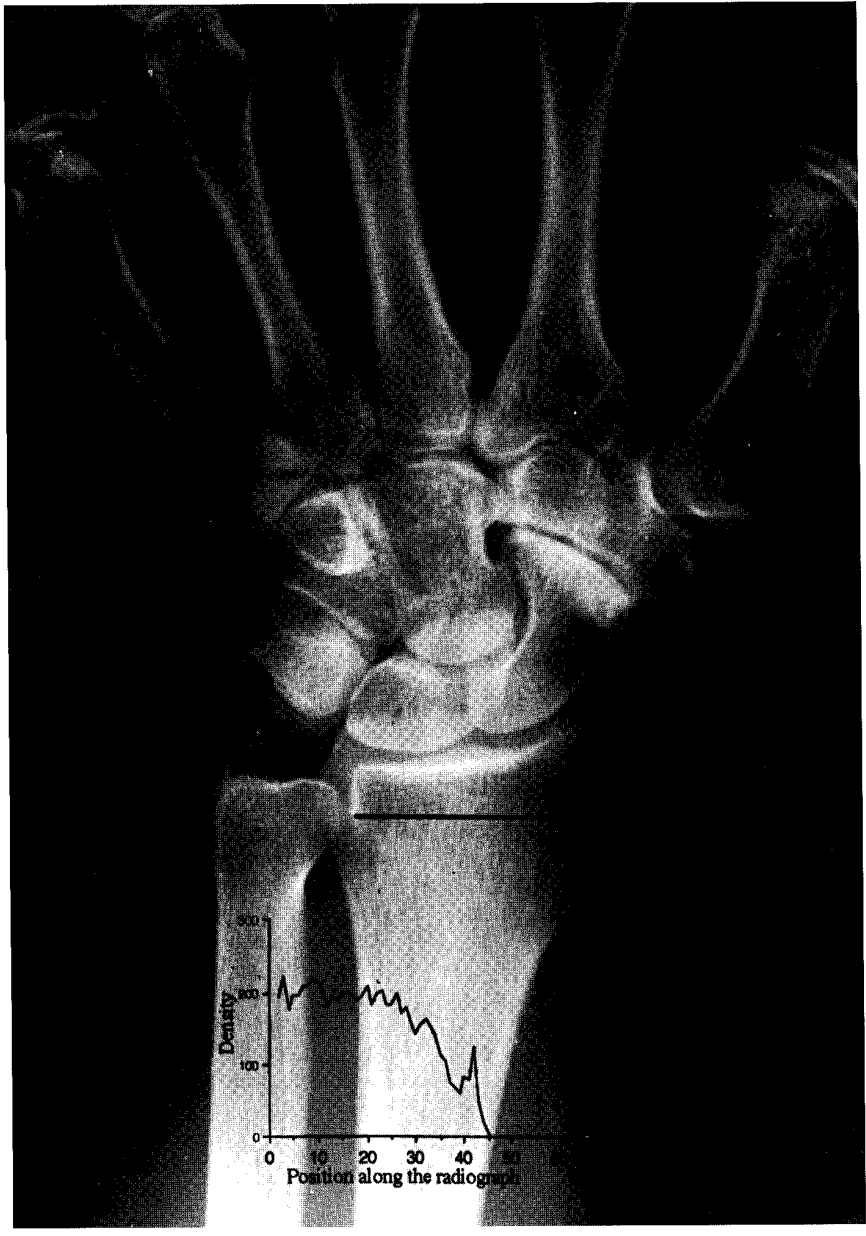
Radiograph of left hand and wrist with densitograph produced by the image analyzer.
